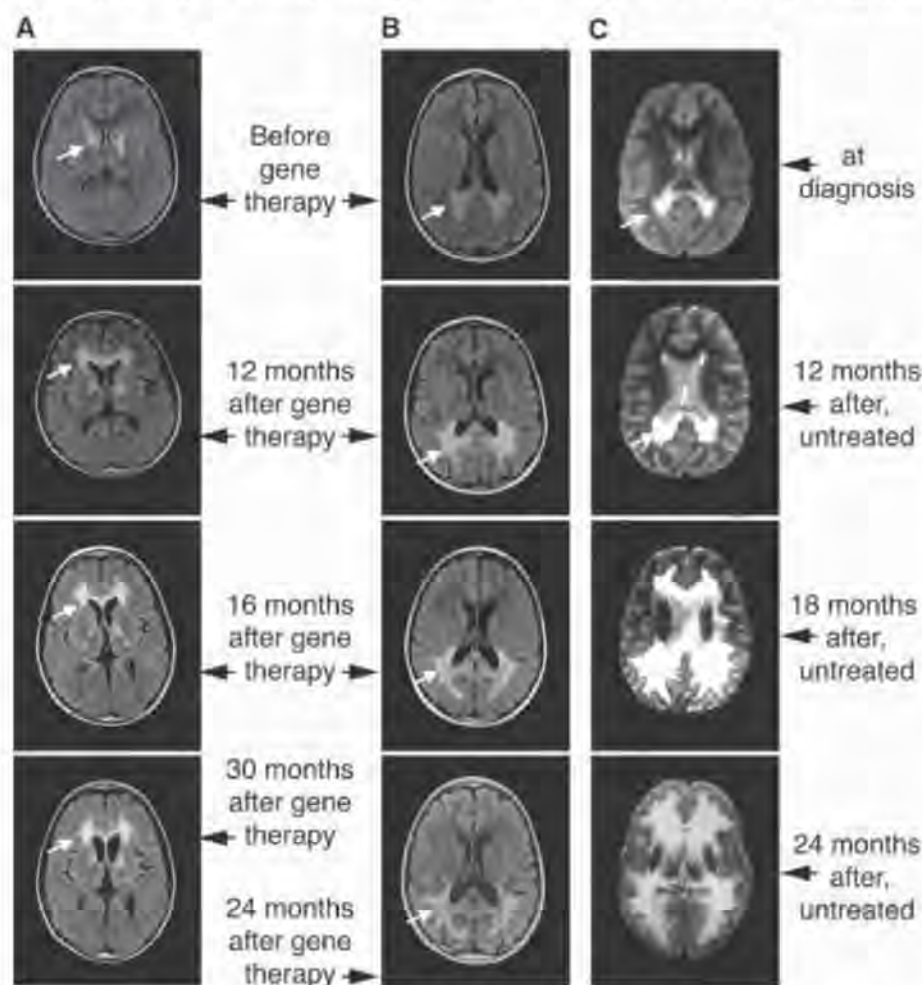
Brain MRIs from P1 (A) and P2 (B) before and after gene therapy. (A) Fluid attenuated inversion recovery (FLAIR) sequences show hypersignal involving the pyramidal tracts within the internal capsules (white arrows) and periventricular frontal white matter of P1 before gene therapy. These lesions extended into the frontal white matter up to 14 months after HSC gene therapy and then did not show progression. (B) In P2, FLAIR sequences show hypersignal involving the corpus callosum, the parieto-occipital white matter (white arrows), and the auditory pathways before gene therapy. These lesions extended into the white matter of posterior parietal lobes up to 16 months after gene therapy and then stabilized with no further progression. (A and B) A mild dilation of frontal (P1) or occipital (P2) horns of ventricle is present 20 to 24 months after gene therapy. (C) Progression of cerebral demyelinating lesions in an untreated 8-year-old ALD patient (demyelination score at 26, 24 months after diagnosis).
